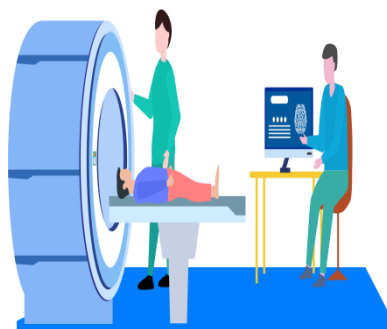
MRI Examination
